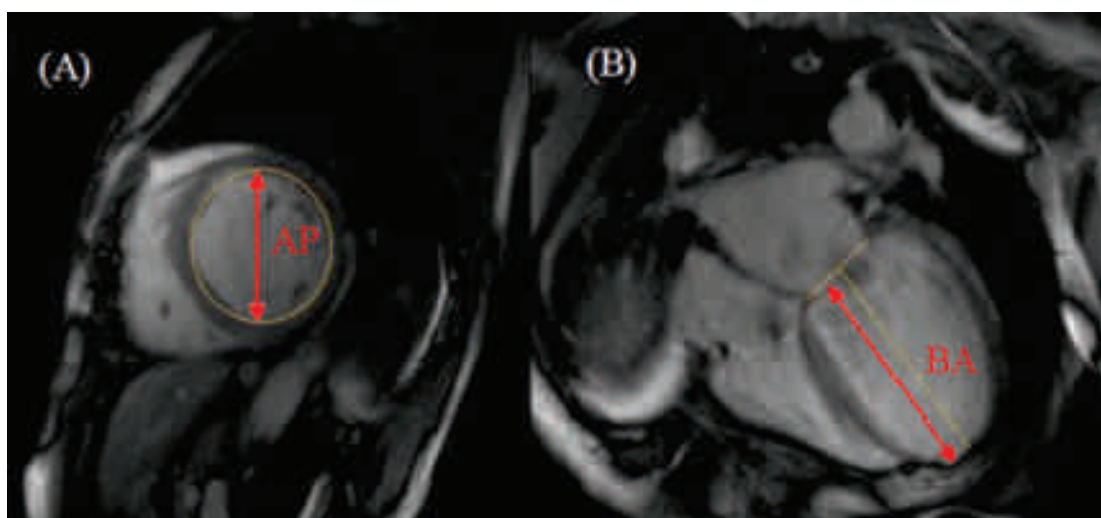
Short-axis (panel A) and long-axis (panel B) magnetic resonance images of a patient. The Anterior-posterior (AP) and base-apex (BA) were measured from 2-D CMR imaging. The shape factor S, eccentricity index E, and sphericity index (SI) can then be calculated from Equations(15) and (16). This figure is adopted from our work in [5].
